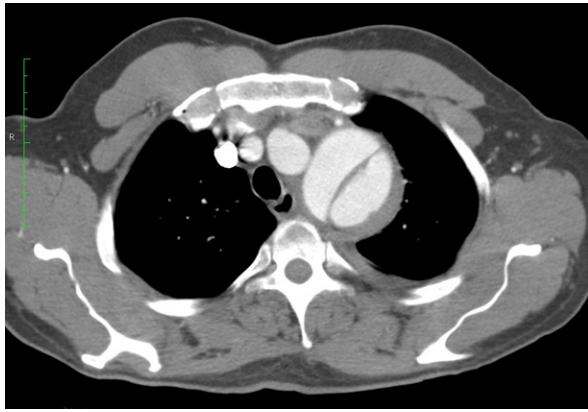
Preoperative contrast-enhanced computed tomogram shows the dissecting aneurysm of the descending thoracic aorta, distal to the origin of the left subclavian artery.
